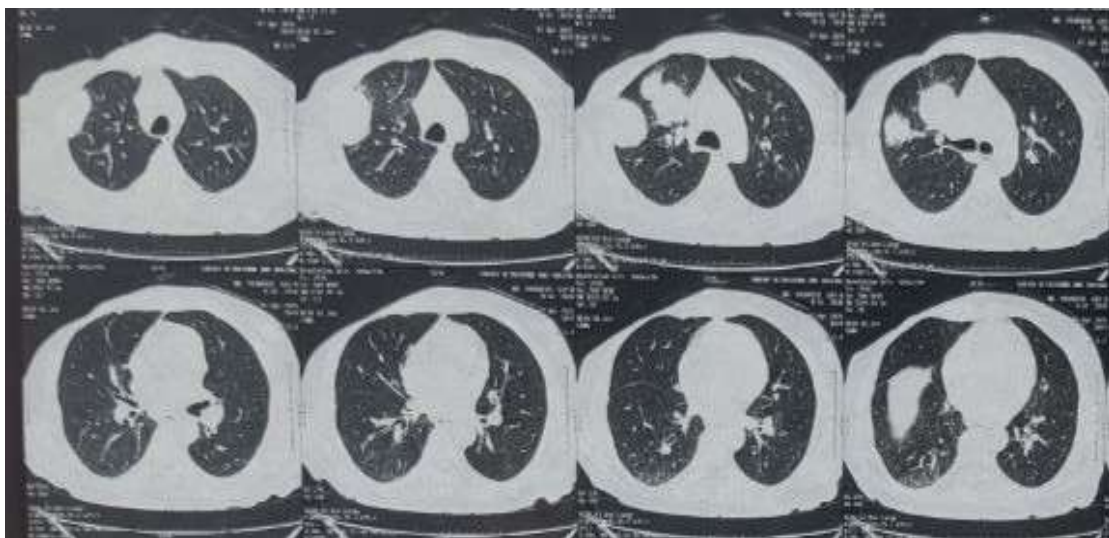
HRCT scan of the chest revealed a large right perihilar heterogeneously enhancing pulmonary solid mass lesion involving right upper lobe.
